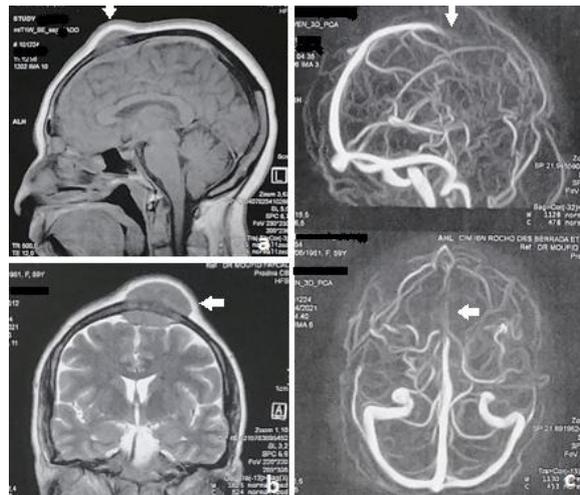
Preoperative cerebral MRI. a Sagittal T1-weighted image shows a bone lesion with exo and endocranial extension. b Coronal T2-weighted image shows superior sagittal sinus infiltration. c MRI-angiogram shows obstruction of the anterior third of the superior sagittal sinus.
